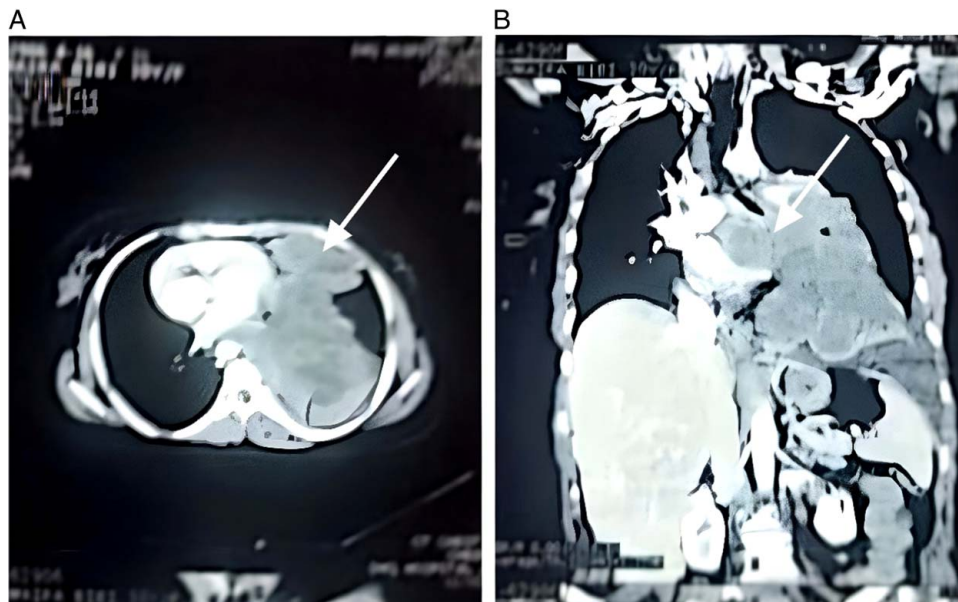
Axial (A) and coronal (B) images of contrast computed tomography chest showing a large lobulated heterogeneous enhancing soft tissue attenuation mass filling lower 2/3rd of left hemithorax, medially infiltrating mediastinal mass encasing left hilar vessels and compressing left lower lobe bronchus (white arrows).
